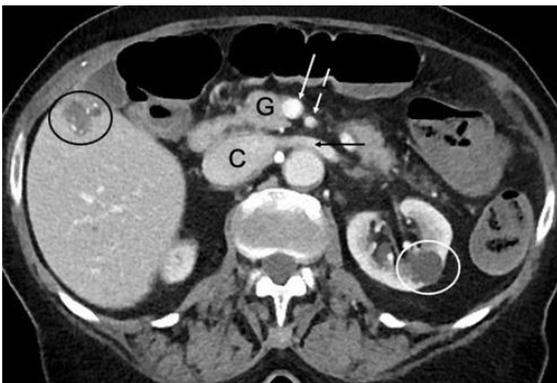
A contrast-enhanced CT abdomen of an 85-year-old female with sigmoid colon carcinoma shows a heterogeneously enhancing hypodense lesion with some peripheral enhancement in the right lobe of the liver anteriorly (black circle). In the given clinical context this lesion is suspicious of a metastasis. However, a hemangioma can have a similar appearance on CT and is a differential consideration. A round non-enhancing
